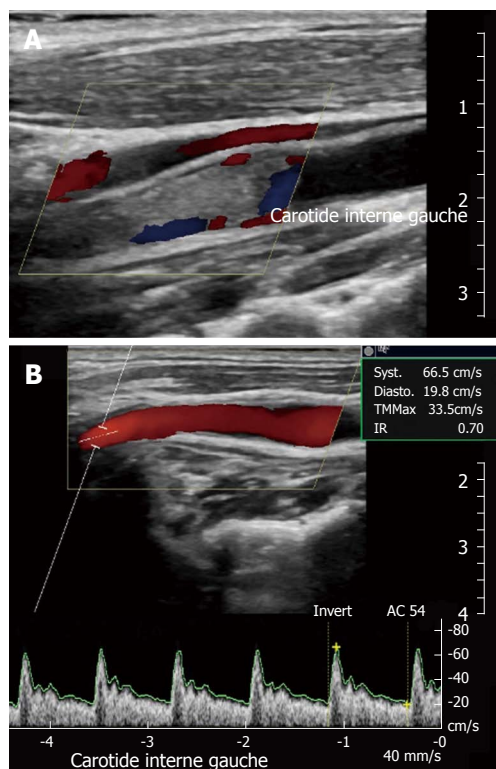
Cervical ultrasonographies in case 1, showing occlusion of the left internal carotid (A), due to a thrombus, and repermeabilization of the vessel with tiny plaque (B) after 15 d of treatment.
